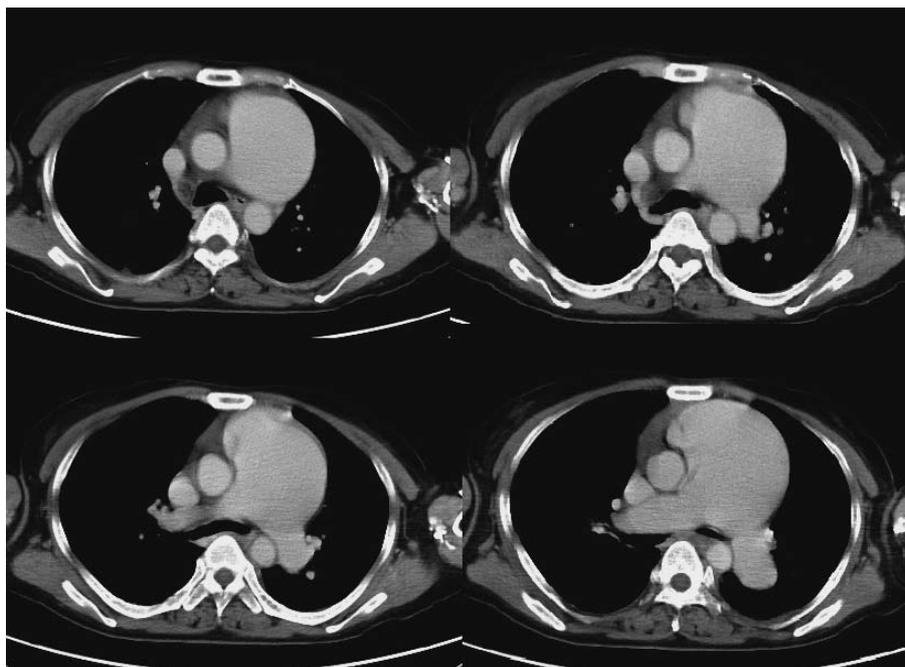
Computed tomography revealed an 6.1cm in diameter in the main pulmonary artery.
